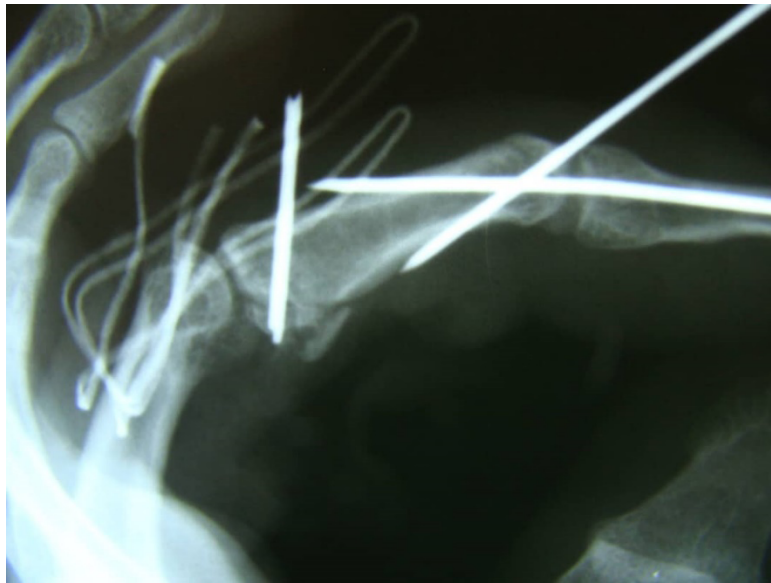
Postoperative radiographic finding
